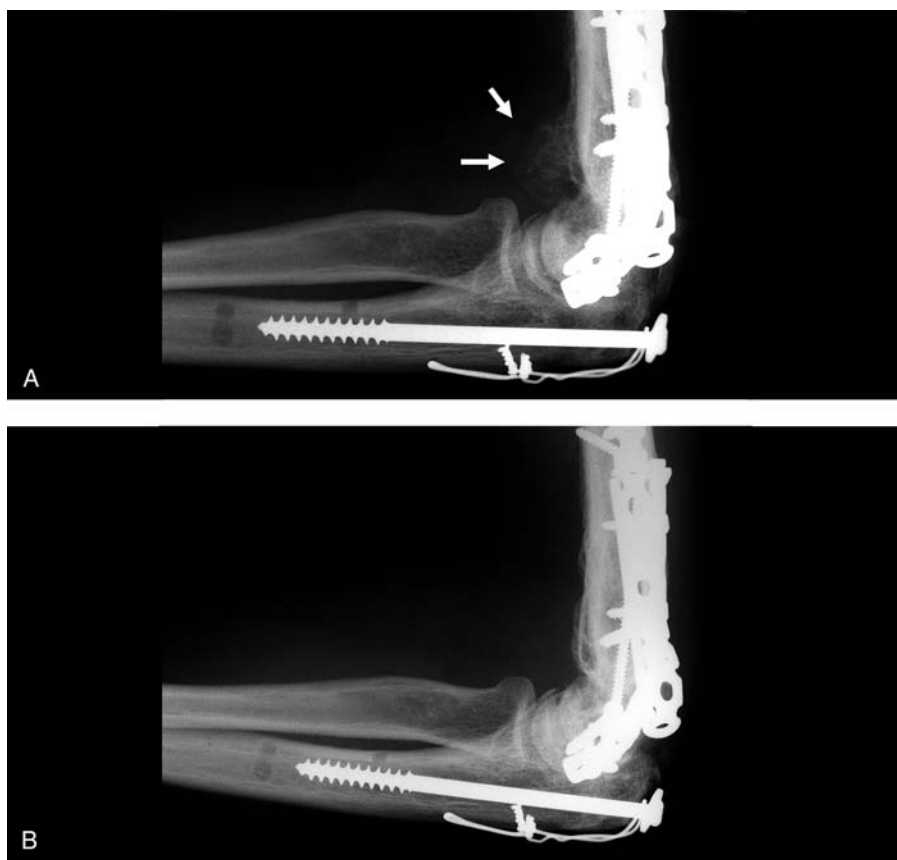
A, Radiograph of mature-appearing heterotopic ossification after surgical treatment of an open distal humeral fracture. The arrows indicate heterotopic bone that formed anterior to the distal humerus and was blocking elbow flexion. B, The heterotopic bone was successfully excised 8 months after the original treatment.
